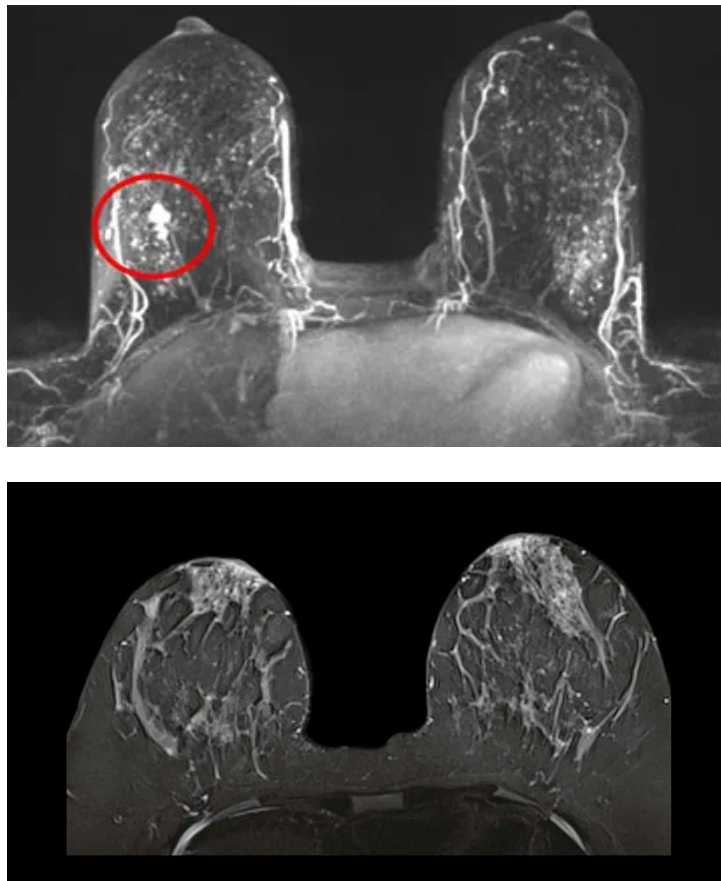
X-Ray of Human Breasts
